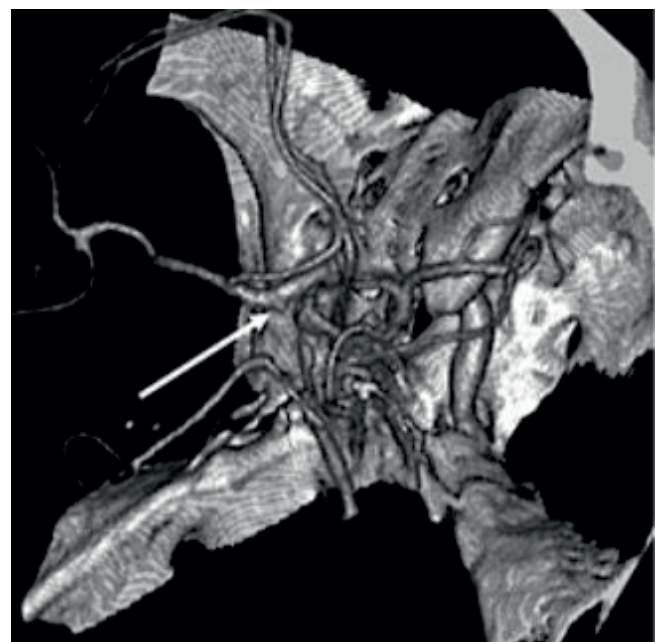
Cerebral computed tomographic angiography revealed a ruptured aneurysm on the left internal carotid artery (arrow: left internal carotid artery aneurysm)
